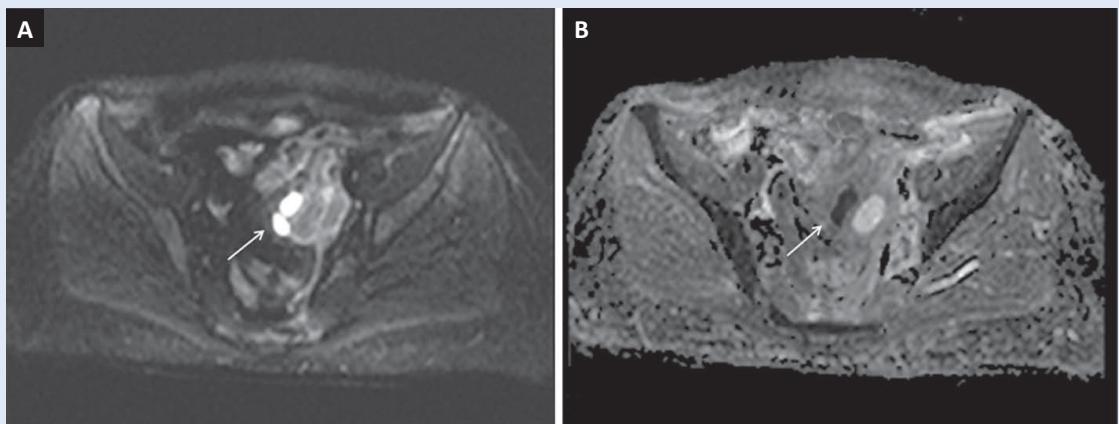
Tubo-ovarian abscess with a diffusion restriction in cystic and no diffusion restriction in solid areas on DWI (A) and ADC map (B).
